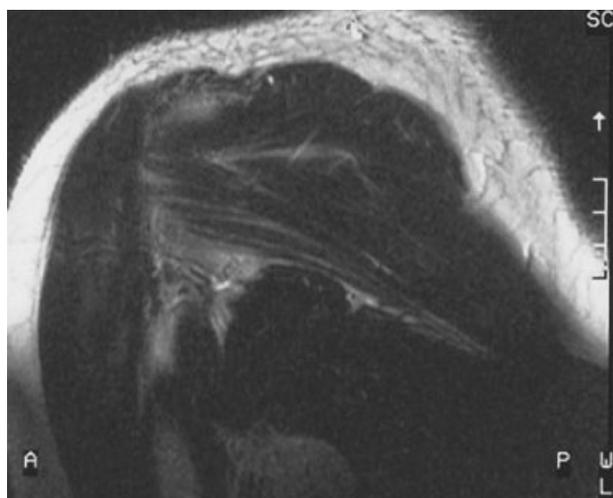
T2-weighted TSE coronal MR image at the level of teres minor shows the increase of signal intensity with a slight decrease in size of the muscle.
